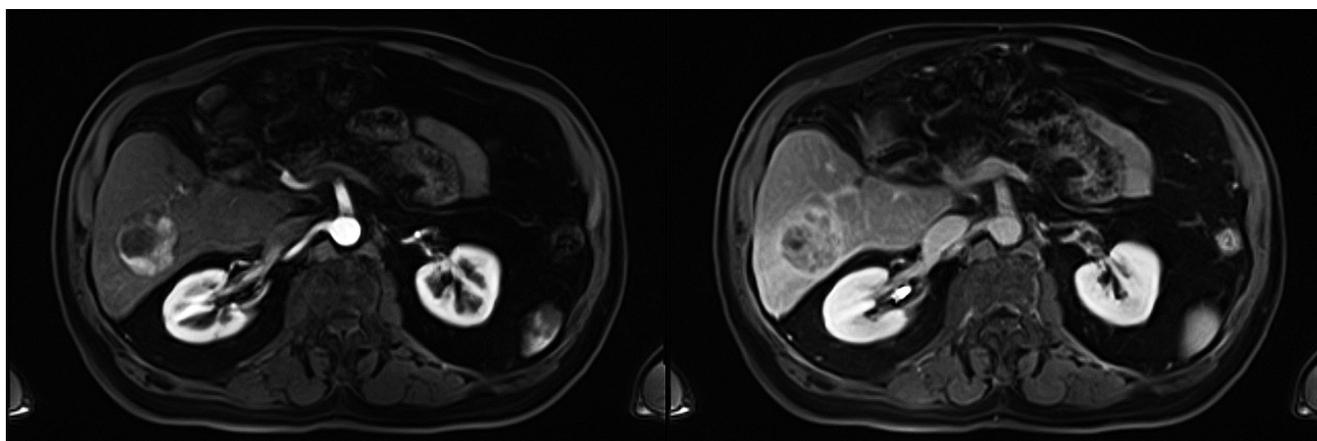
Magnetic resonance imaging with gadolinium showing a 3.7 cm lesion in the right hepatic lobe which meets the criteria for hepatocellular carcinoma. Enhancement of arterial phase and portal phase lavage.
